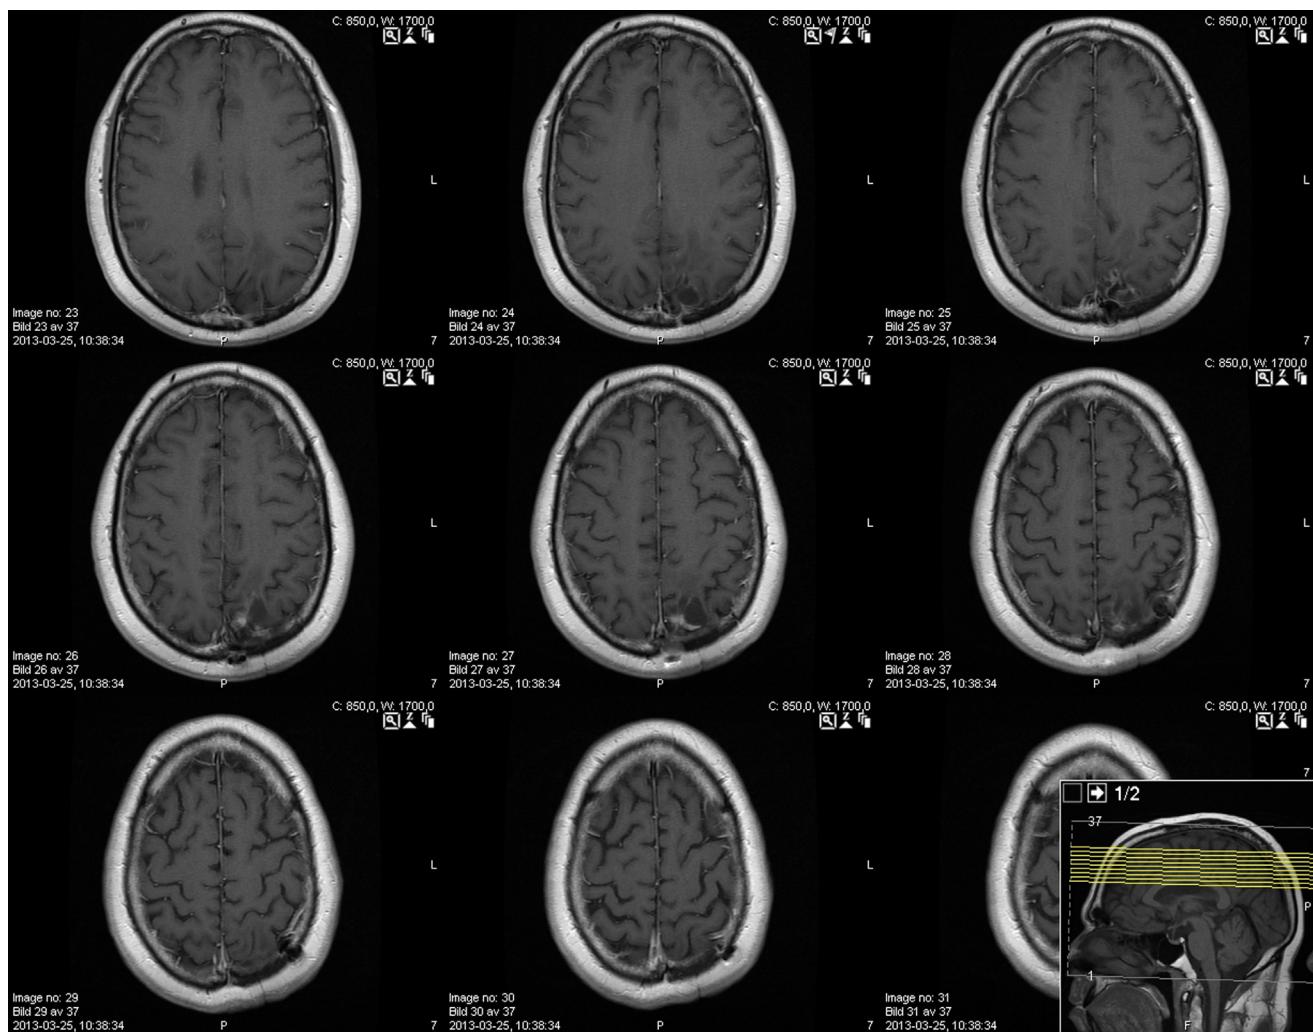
Follow up magnetic resonance imaging; March 2013.
